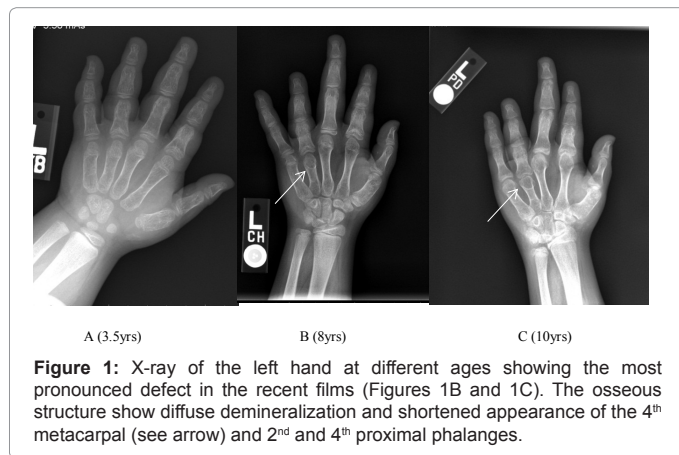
X-ray of the left hand at different ages showing the most pronounced defect in the recent films (Figures 1B and 1C). The osseous structure show diffuse demineralization and shortened appearance of the 4th metacarpal (see arrow) and 2nd and 4th proximal phalanges.
